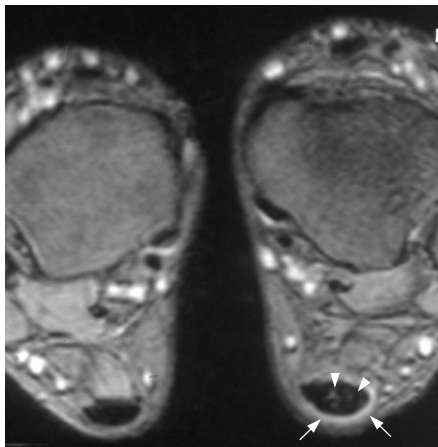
Peritendinitis in male marathon runner. Axial T2-weighted spin-echo MR image at the level of the talus shows fluid (arrows) around the posterior aspect of the Achilles tendon. The tendon is also slightly thickened with subtle intratendinous signal intensity (arrowheads)
